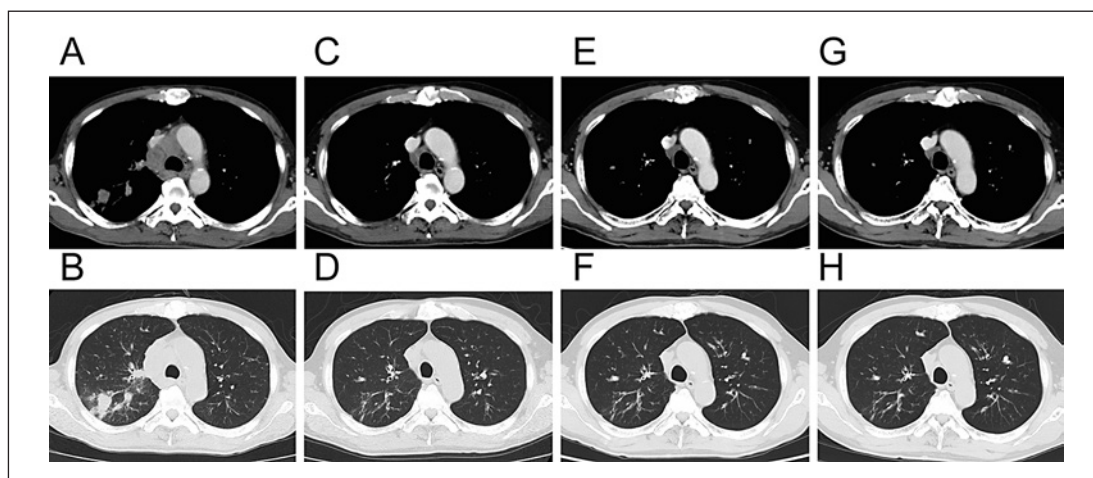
Computed tomography images of the lung tumor immediately before the administration of alectinib (A, B), after initial alectinib-induced hepatotoxicity (C, D), after second-time alectinib-induced hepatotoxicity (E, F), and 4 months after the initiation of lorlatinib (G, H). The right upper primary lung tumors almost disappeared at 3 and 7 months after alectinib therapy and 4 months after lorlatinib therapy.
